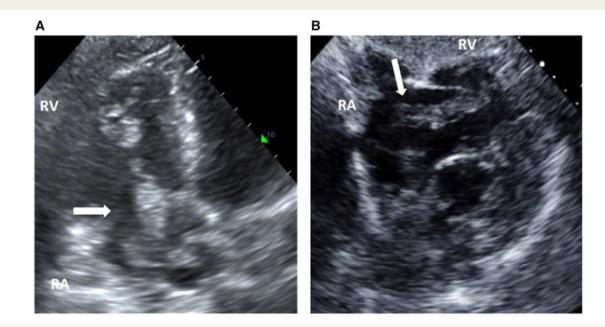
Echocardiogram (A) four-chamber view showing dilated right ventricle, and clot in transit (arrow), (B) subcostal view with clot in transit (arrow) through the right atrium to the right ventricle.
